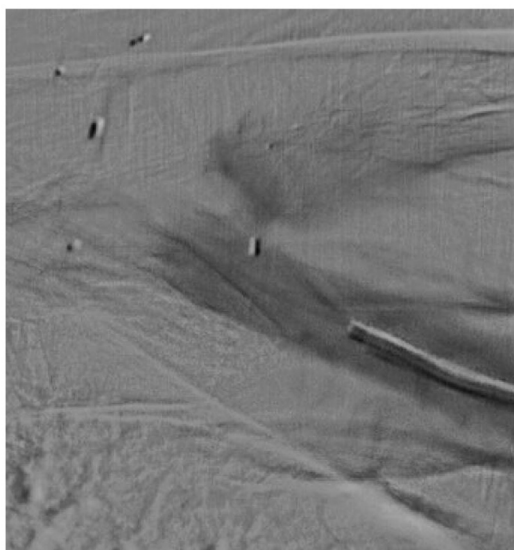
Blood flow persisting into left subclavian artery pseudoaneurysm after microvascular plug (MVP) deployment and 1 mL of direct thrombin injection under ultrasound guidance.
